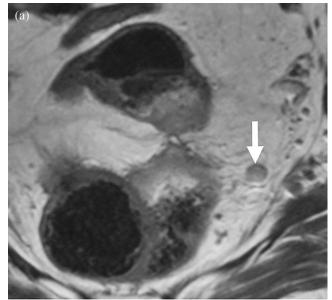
Regression of lymph node from the mesorectal fascia. (a) Pretreatment T2-weighted magnetic resonance image showing a malignant node (arrowhead) with heterogeneous signal intensity and irregular outline in the left mesorectum close to the mesorectal fascia (arrow). (b) After chemoradiation treatment, there was regression of the node (arrowhead) from the mesorectal fascia (arrow).
